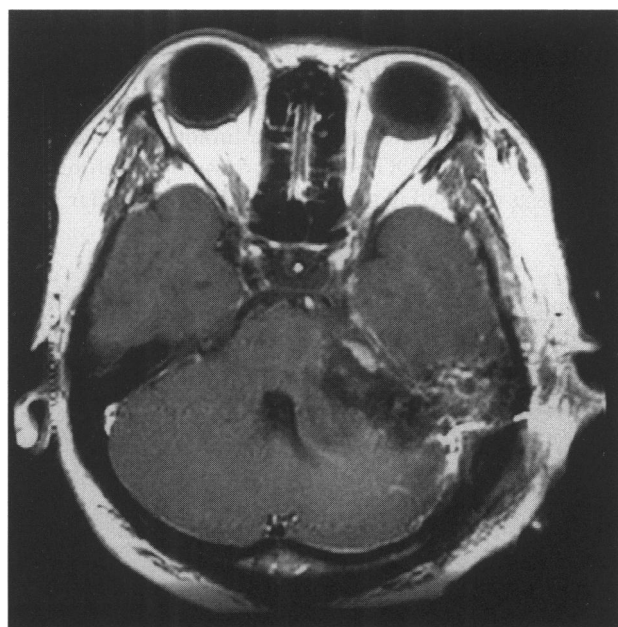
Postoperative MRI in Case 1.
